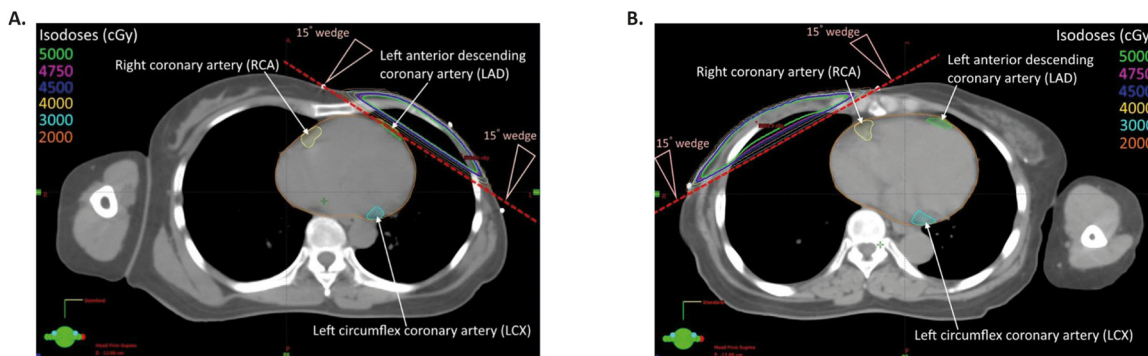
Dose distribution in left-sided and right-sided breast cancer irradiation. Treatment planning CT-scans showing the dose distribution from 6MN tangential irradiation in left-sided and right-sided breast cancer after mastectomy. The organs at risk, including the heart, left anterior descending coronary artery, left circumflex artery, and right coronary artery are outlined. (Reprinted with permission from Lai et al.⁵²)
